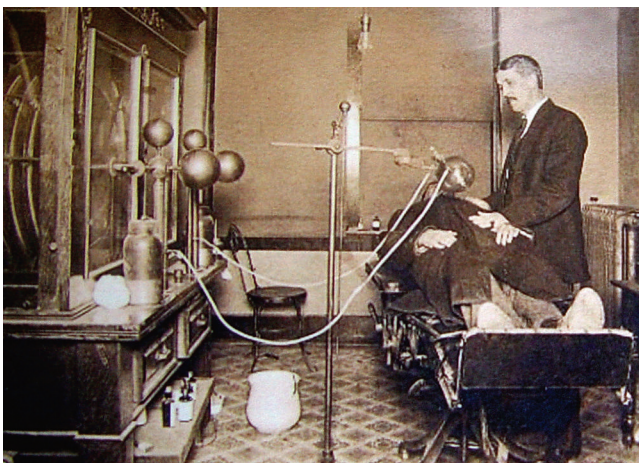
1900s Physician's Office. Image of circa 1900 x-ray machine setup in a physician's office. Note the x-ray tube suspended above the patient and the open nature of the electrical wiring and tube. (Photo courtesy Alex Peck Medical Antiques.)
